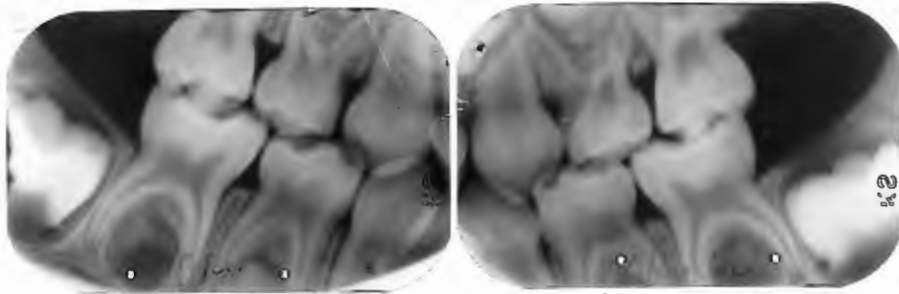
Bitewing radiographs of two three-year-old girls who had severe neonatal rickets because of extreme prematurity of birth (Cases 10 and 11, Table 3.1).
